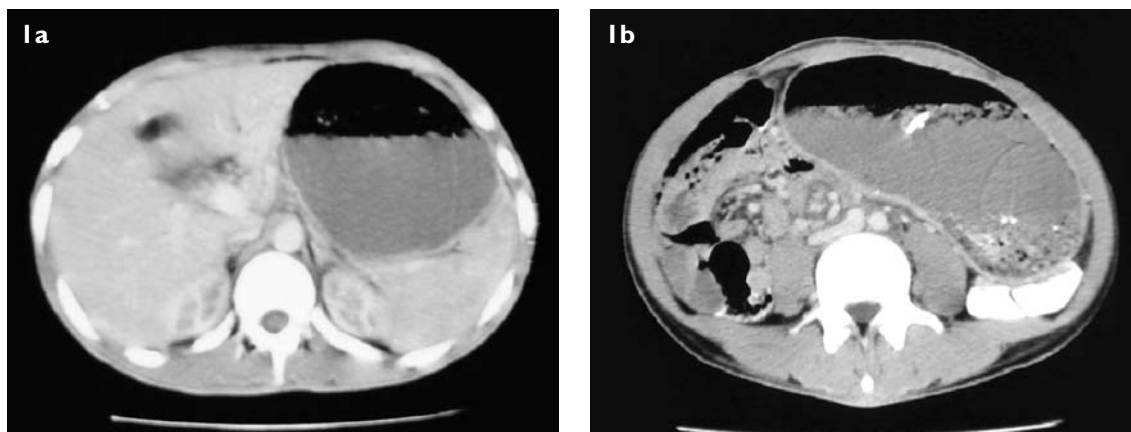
Axial CT images show (a) non-visualisation of the gallbladder, and (b) enormous dilatation of the stomach.
